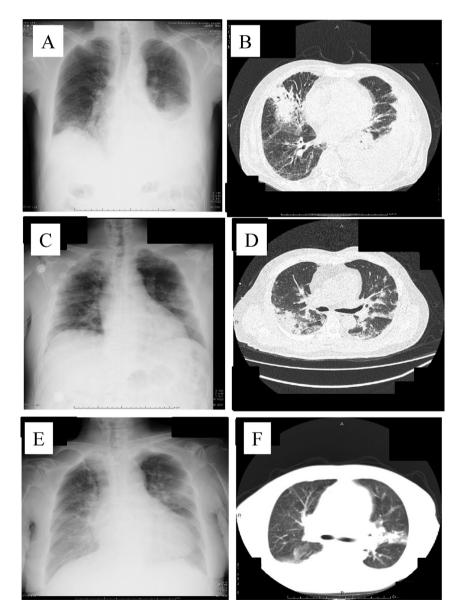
Chest radiography and computed tomography images of Case 1 (A and B), Case 2 (C and D), and Case 3 (E and F). All images showed infiltration shadows and pleural effusions, suggested severe pneumonia/empyema.
